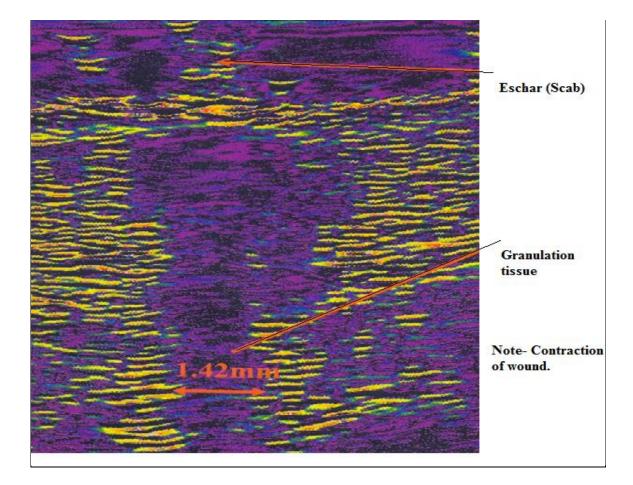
Shows high resolution ultrasounds scan of healing skin 14 days after a full thickness punch biopsy (Taken from Morison et al, 2004).
